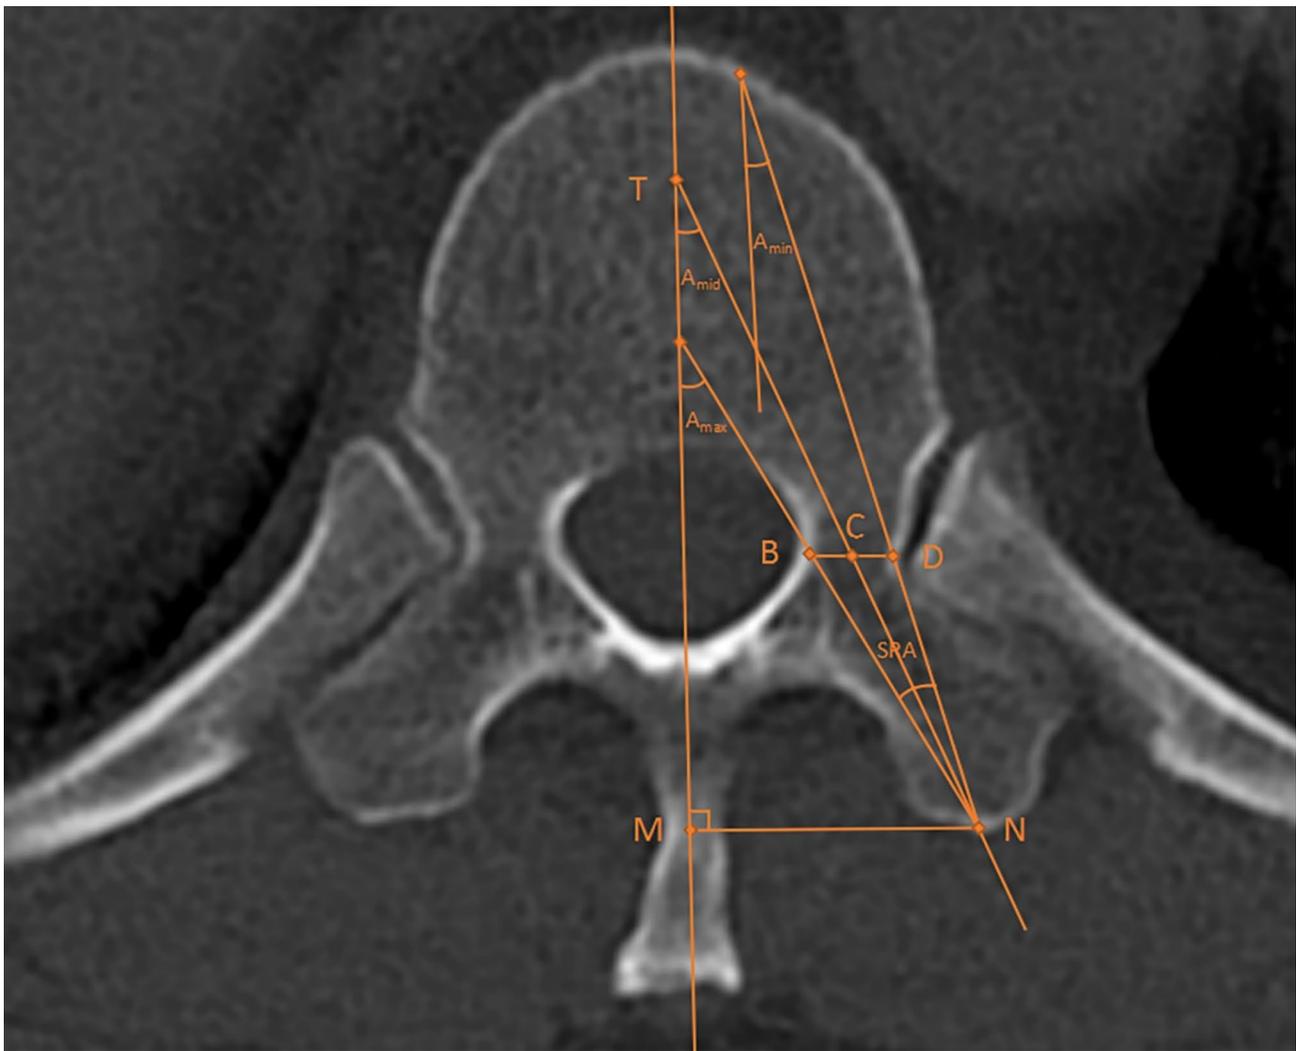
Measurement of the DEM, MTPW, and angles. TM indicates the midline of the vertebral body, and the target point T is positioned at the anterior one-third of this line. N indicates the bone entry puncture point in the UTPPA, where the puncture course intersects with the transverse process through the selected slice on CT. MN indicates the distance between the bone entry puncture point and the midline (DEM). B and D indicate the inner edges of the medial and lateral cortex of the narrowest pedicle on the selected CT slice, respectively. BD indicates the minimum transverse pedicle width (MTPW). C indicates the crossing point between the puncture path and BD. When point C is between B and D, the puncture can be considered as a successful puncture. The puncture inner inclination angle (PIA) was the angle measured between the midline and the puncture course. When point C is the midpoint of BD, CN is the middle puncture path, and A_{mid} indicates the middle PIA. A_{max} indicates the maximum PIA. A_{min} indicates the minimum PIA. The safe range of the PIA ($SRA = A_{max} - A_{min}$) can be calculated, within which the puncture could be completed safely
